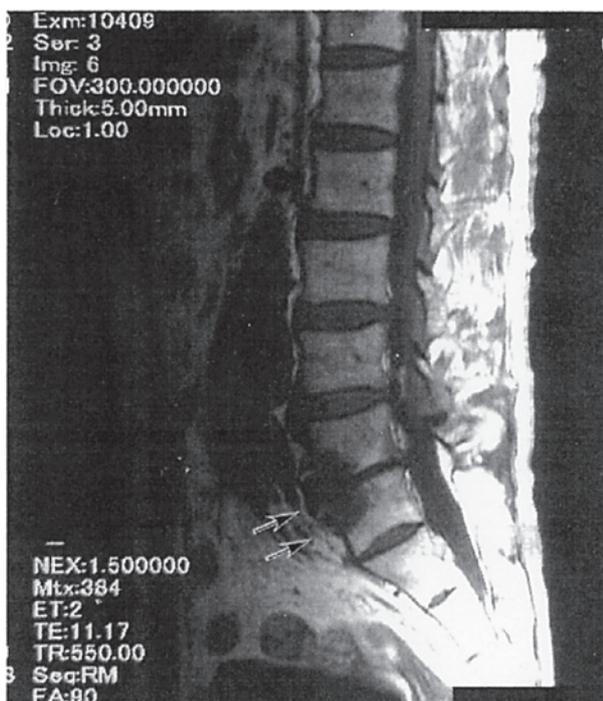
MR imaging showed a pyogenic discitis and osteomyelitis at L4/5 vertebral bone(→).(CASE4)
